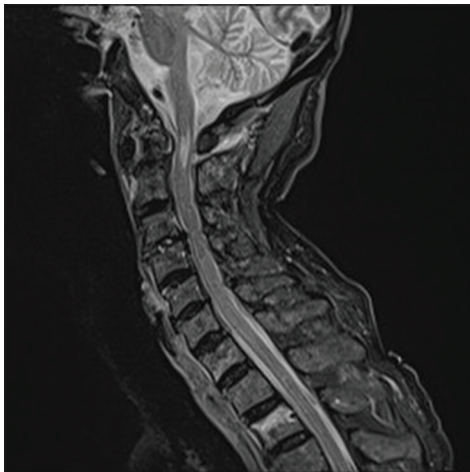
Preoperative sagittal magnetic resonance imaging short-TI inversion recovery sequence demonstrating myelomalacia at C1 and severe stenosis at C3/4 level.
